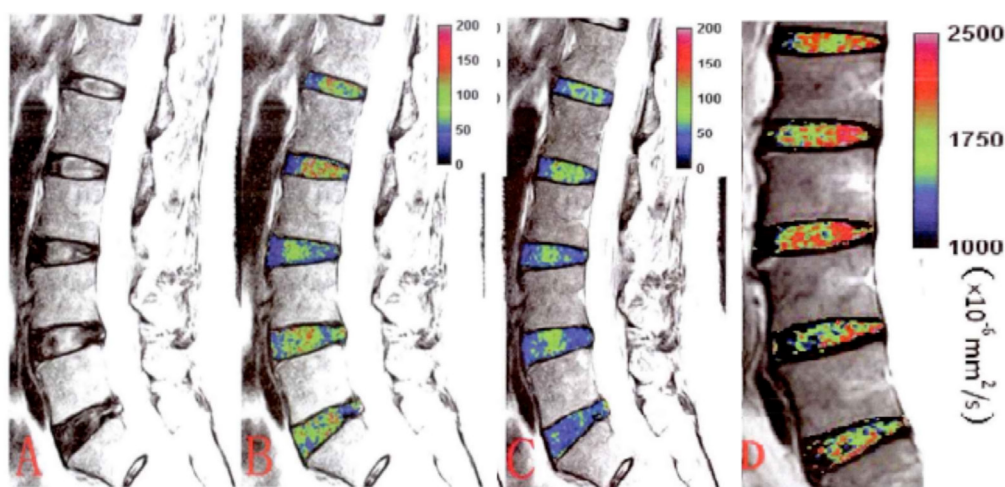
The conventional T2WI (A), T1p (B), T2 mapping (C) and DWI (D) pseudo-color fusion image of grade III and IV intervertebral discs. Panel A shows a L5-S1 intervertebral disc at grade IV. The nucleus pulposus signal was black, and its boundary with the annulus fibrosus disappeared. The remaining discs are grade III, the nucleus pulposus signal is gray, its boundary with the annulus fibrosus is unclear. Panel B shows the nucleus pulposus in low value green, and the annulus fibrosus value is increased. Panel C shows the nucleus pulposus in low value green. Both of them demonstrate the same trend. Change in the amplitude of T2 mapping value of the annulus fibrosus was lower than the change in amplitude of the T1p value. Panel D shows the nucleus pulposus in low value green. The T1p and T2 mapping values were higher than the center of the nucleus pulposus, while the high ADC value was mainly located in the rear of the nucleus pulposus and the difference between nucleus pulposus and annulus fibrosus was more obvious.
